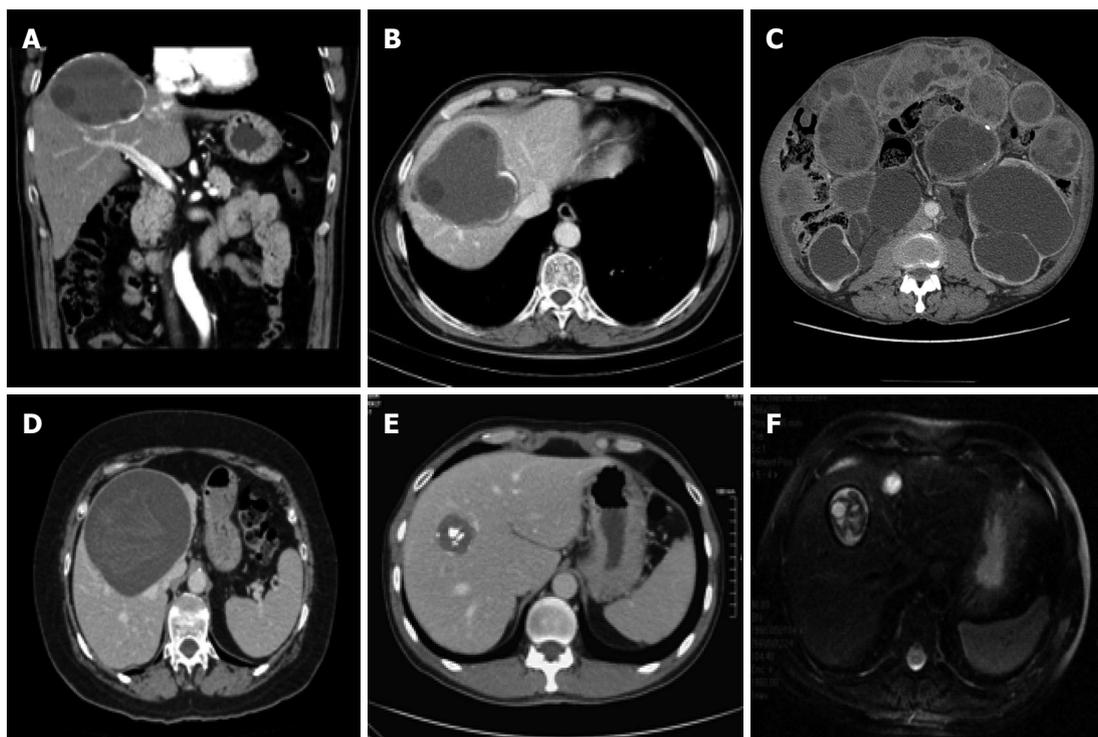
Computed tomography and magnetic resonance imaging of hepatic cystic echinococcosis. A and B: Contrast enhanced computed tomography (CT) abdominal scan of a 59-year-old male patient with a CE3b cyst in the VII liver segment; C: Disseminated peritoneal echinococcosis in 64-year-old male patient, 30 years after surgery for CE without albendazole prophylaxis^[1]; D: Abdominal CT scan of a 59-year-old female patient with a CE3a cyst in the IV-VIII liver segments; E: Abdominal CT scan of a 47-year-old male patient with a CE5 calcified cyst in the VIII liver segment; F: Abdominal magnetic resonance imaging scan of a 52-year-old male patient with a CE3b cyst in the VIII segment.
